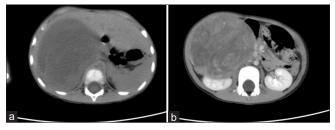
Non-enhancement (3a) and enhancement (3b) images of computed tomography of the abdomen showing a huge calcified tumor with heterogeneous density between the liver and the right kidney
